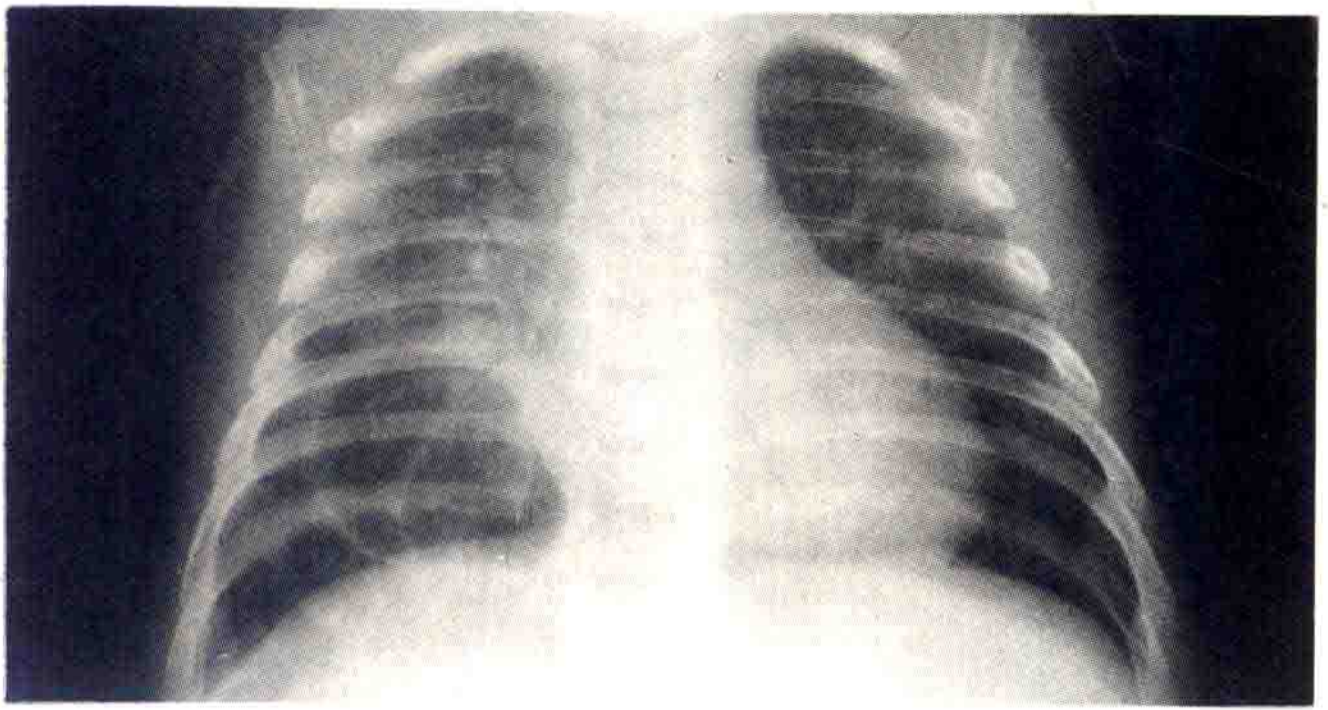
Staphylococcal pneumonia. The syndrome of staphylococcal pneumonia in childhood is characterized by the formation of pneumatocoeles as seen in these radiographs, which may form abscesses and have a tendency to rupture to give a staphylococcal pyopneumothorax.
